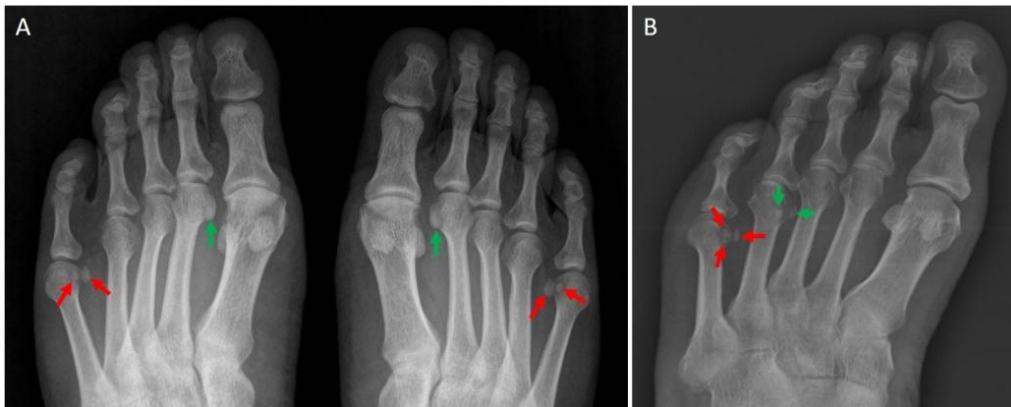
AP radiographs showing a: bilateral bipartite sesamoid bone of the fifth MTP joint (red arrows) and bilateral unipartite sesamoid bone of the second MTP joint (green arrows) in a 46-year-old male, B: tripartite sesamoid bone of the fifth MTP joint (red arrows) and bipartite sesamoid bone of the fourth MTP joint (green arrows) in a 50-year-old female
